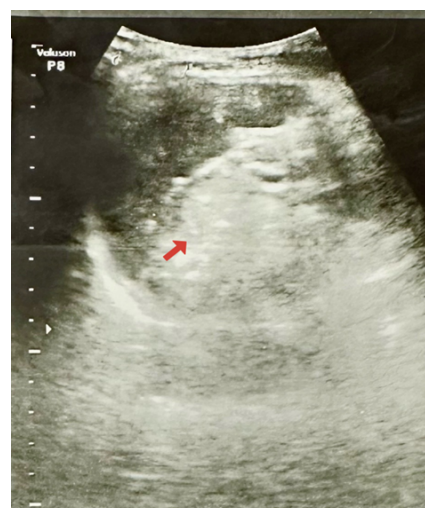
Ultrasonography showed altered echotexture of prostate gland
